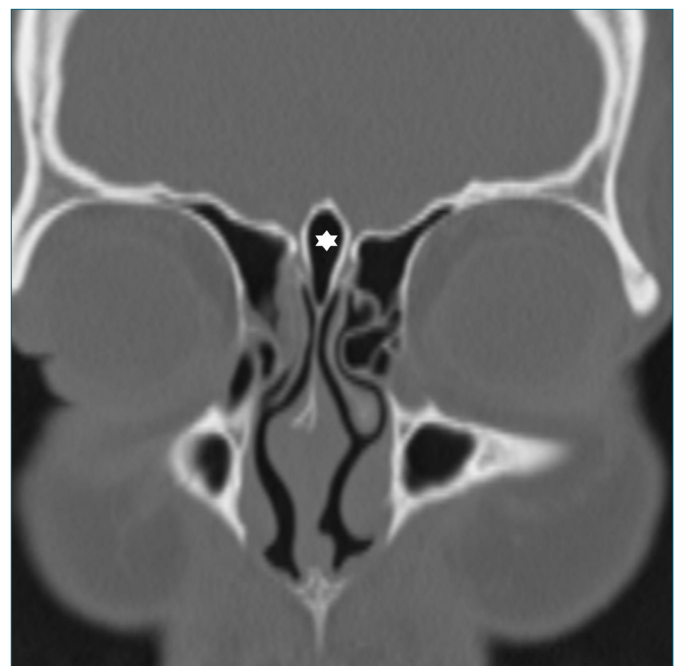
Coronal section CT image, crista galli pneumatization (\*) is shown.
